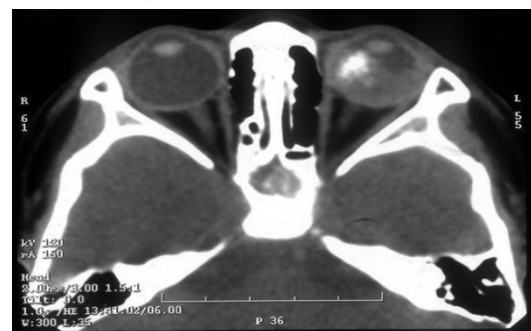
Axial CT Image of Left Eye Retinoblastoma. High-density mass with calcifications within the left eye.
